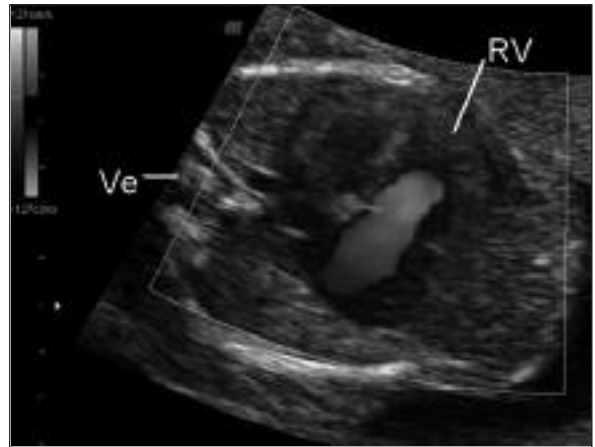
Apical four chamber view of the heart in color Doppler examination showing marked valvular insufficiency. Note the left axis of the heart due to right ventricular (RV) dilatation.
